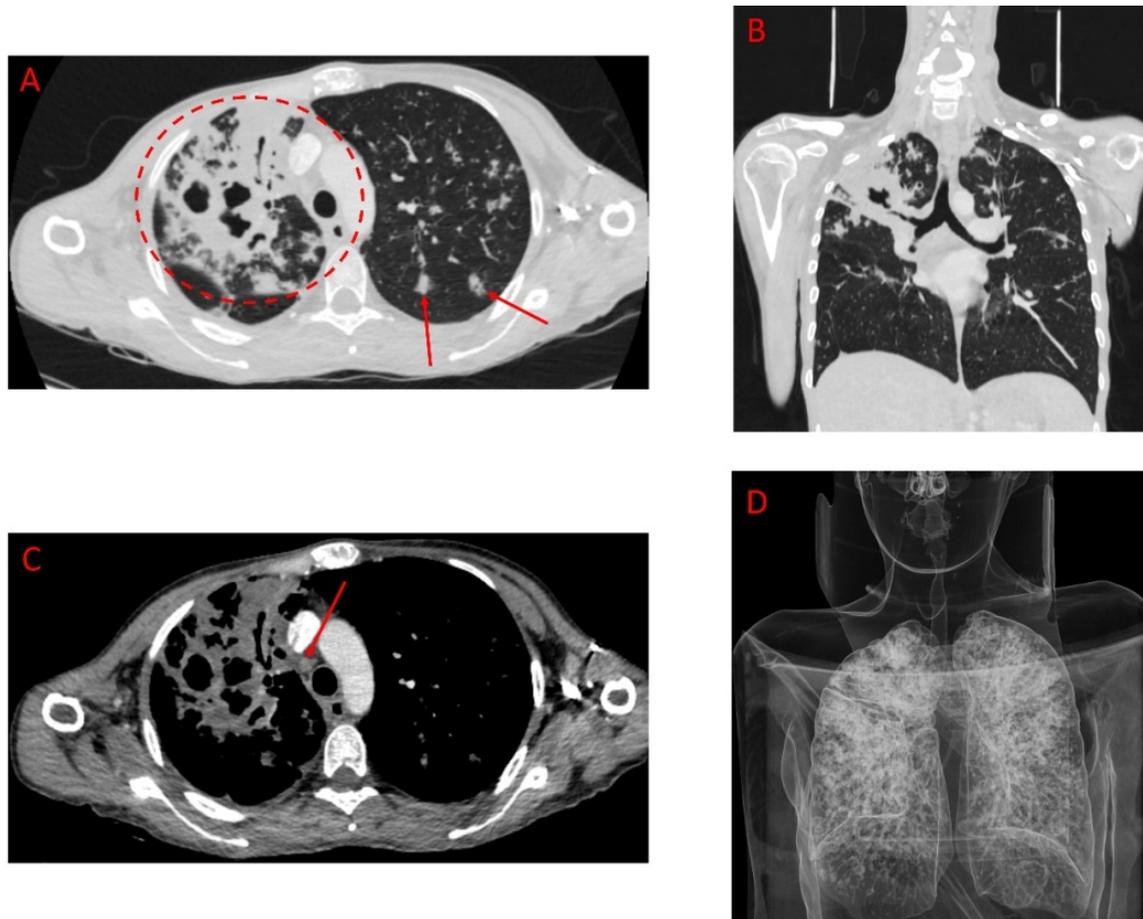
CT thoracic region: A-pulmonary window, encircled area →right upper lobe condensation area with massive cavitation, arrows →focal pulmonary condensation areas bilaterally; B-coronal plane, pulmonary window →pulmonary damage predominantly at the apical portions; C-postcontrast, mediastinal window →right inferior para-tracheal adenopathy; D-3D reconstruction after CT examination →there is a noticeable damage to the lungs predominantly in the upper two thirds, with minimal damage to the basal regions.
